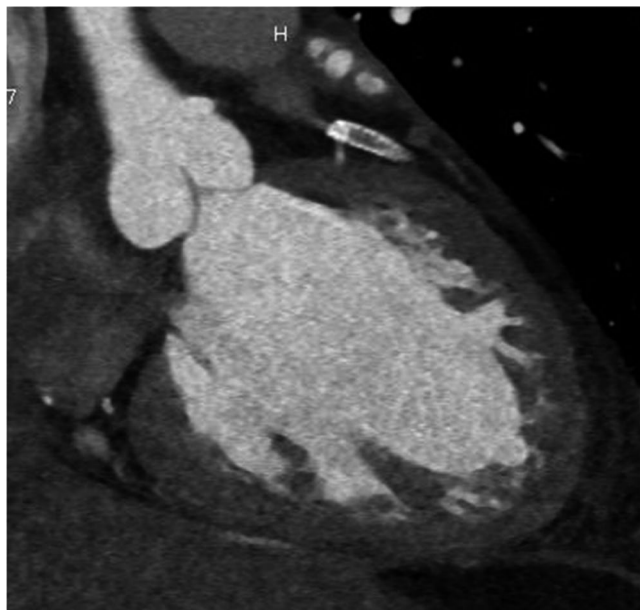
There is no evidence of residual thrombus on postoperative computed tomography
